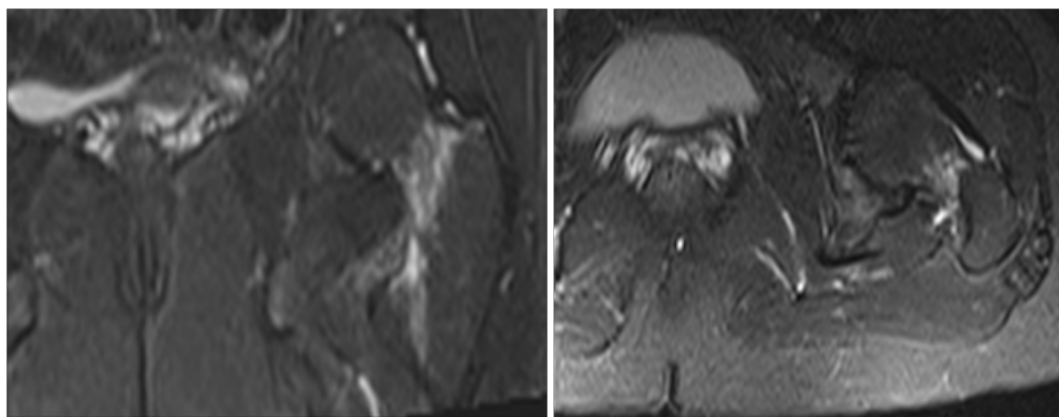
MRI of the left hip, T2 sequence, showing hyperintense signal.
